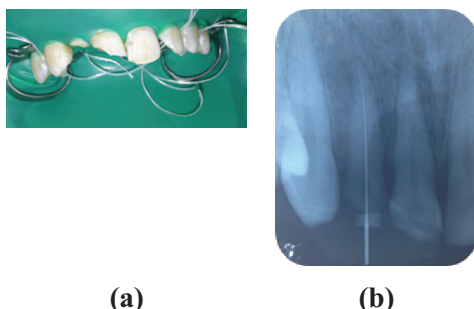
(a) the installation of the rubber dam; (b) the radiograph to measure the length of the work.
